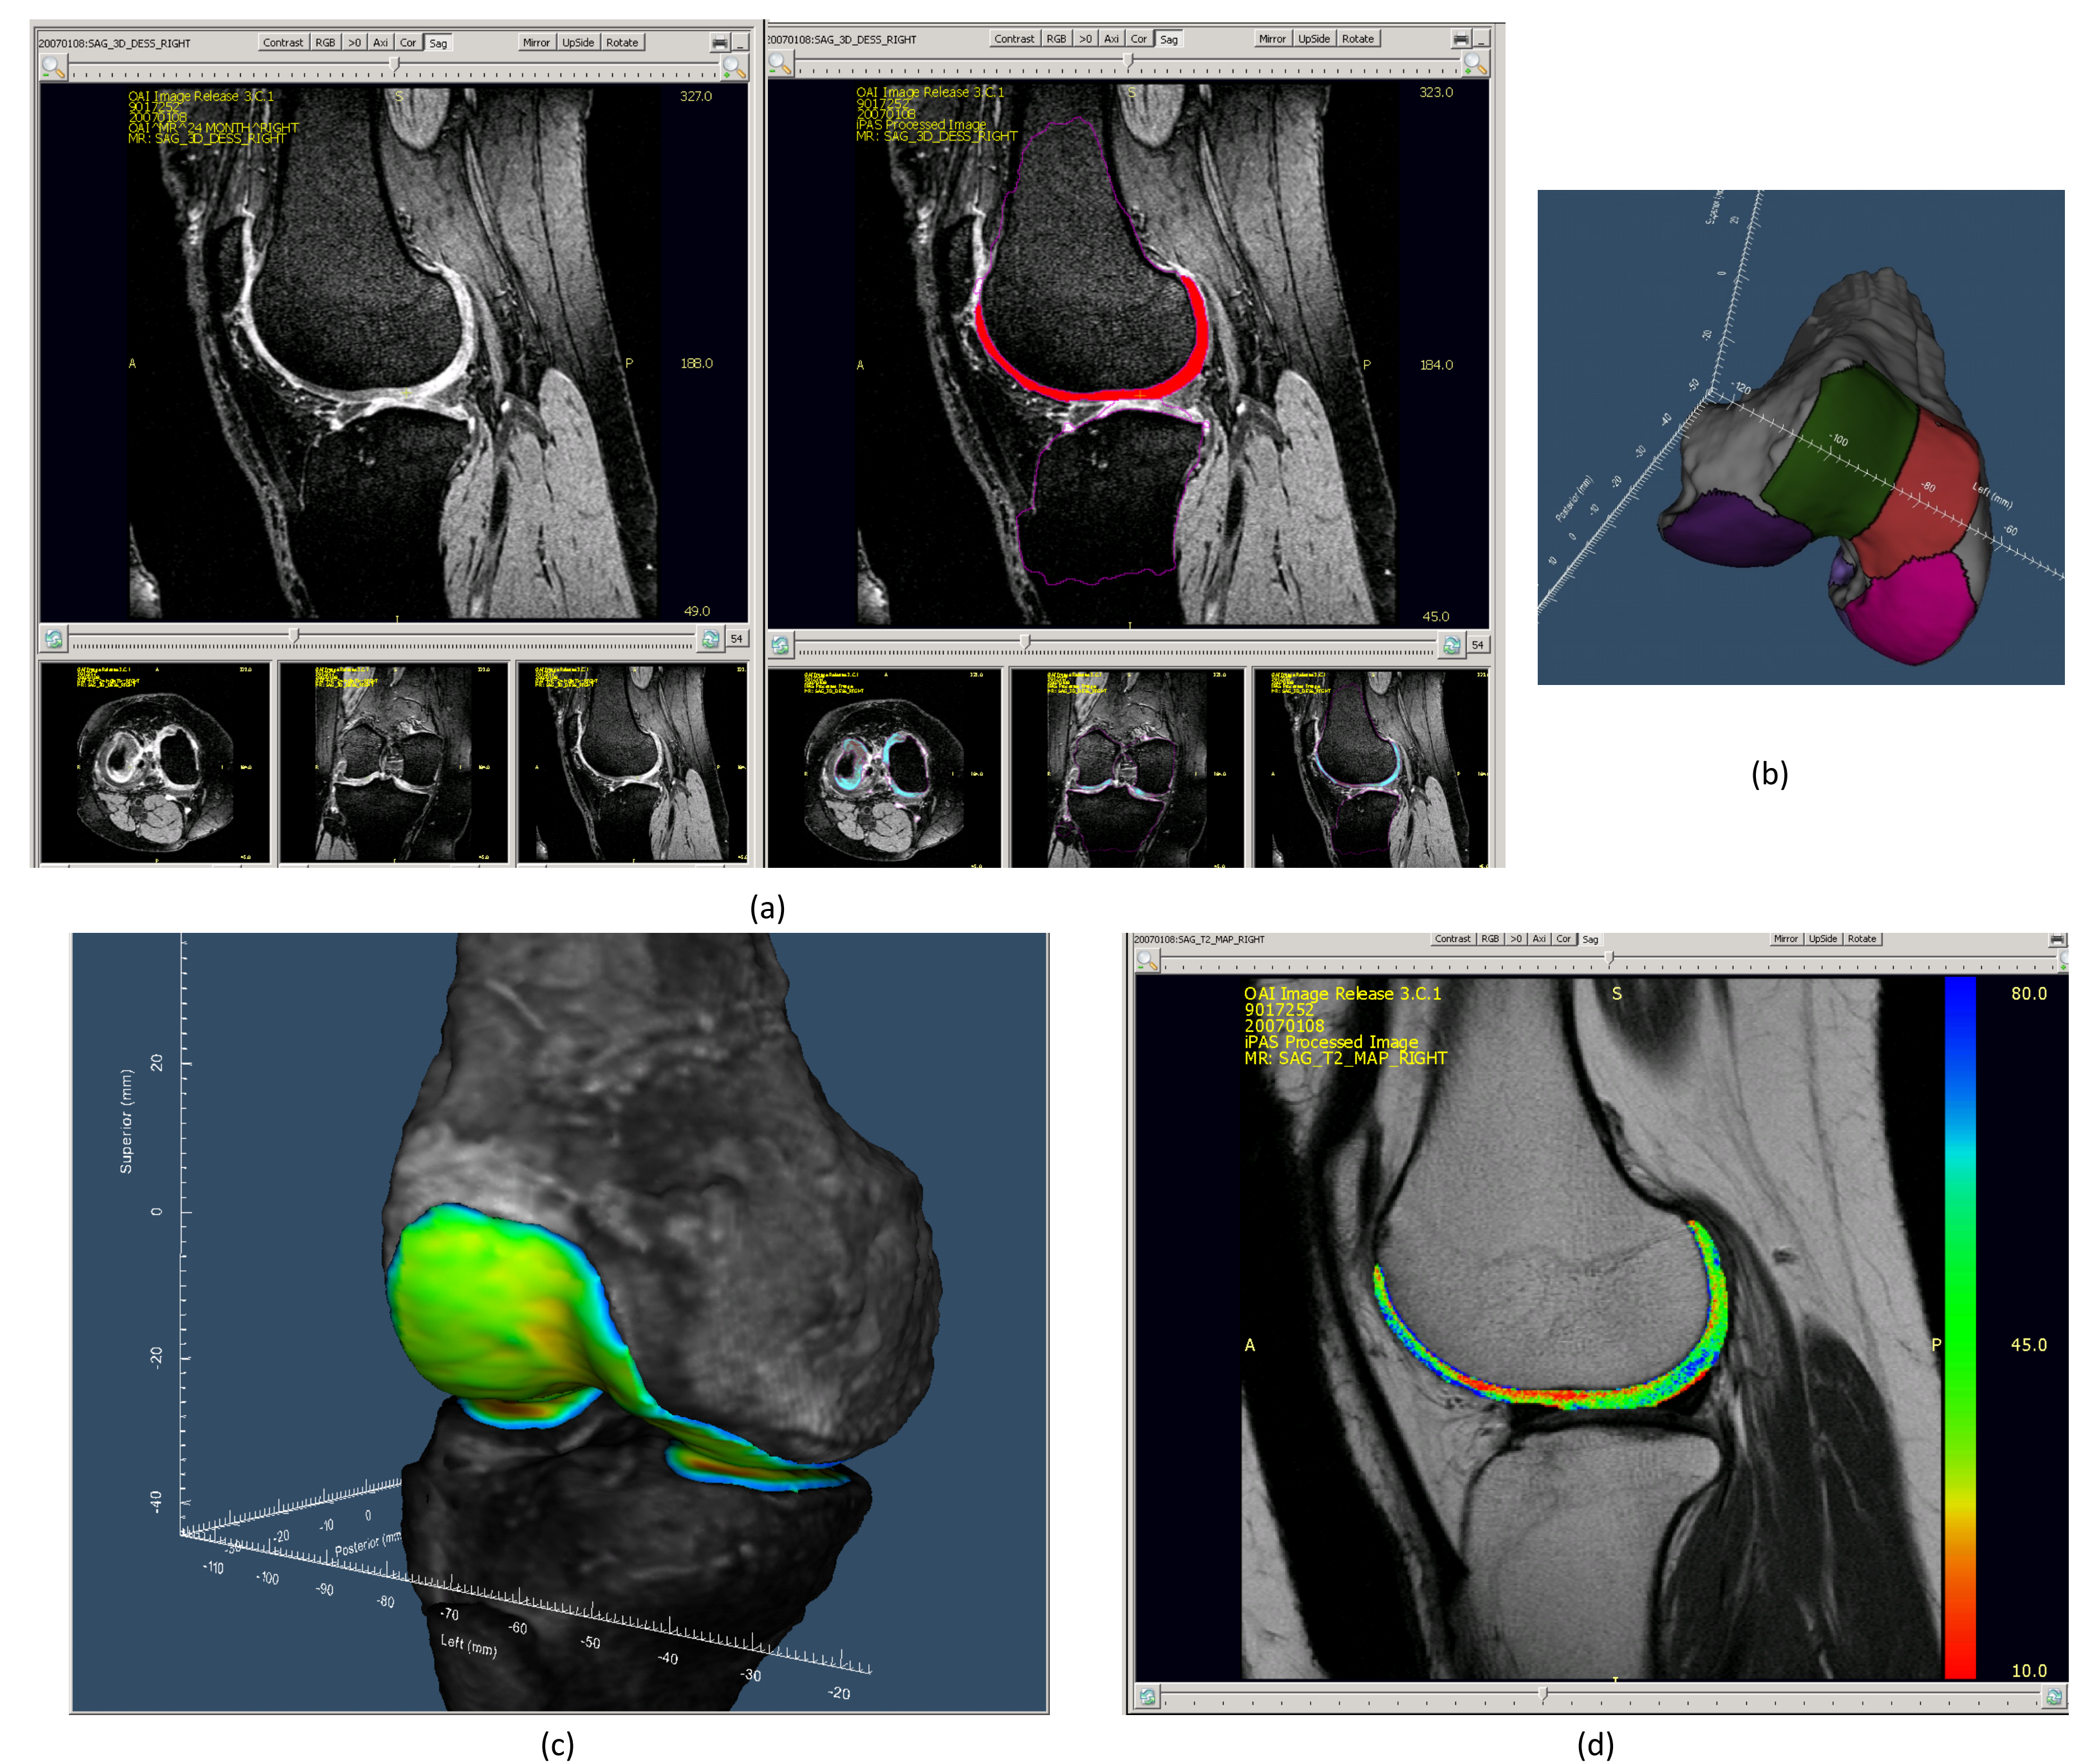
(a) DESS images were automatically segmented to extract the cartilage tissue. (b) Regions of interest of the MRI analysis. (c) 3D visualization of the segmented cartilage tissue. (d) The DESS segmentation was co-registered to the 2D MESE OAI T2 series where colors show the T2 Values of femur cartilage.
